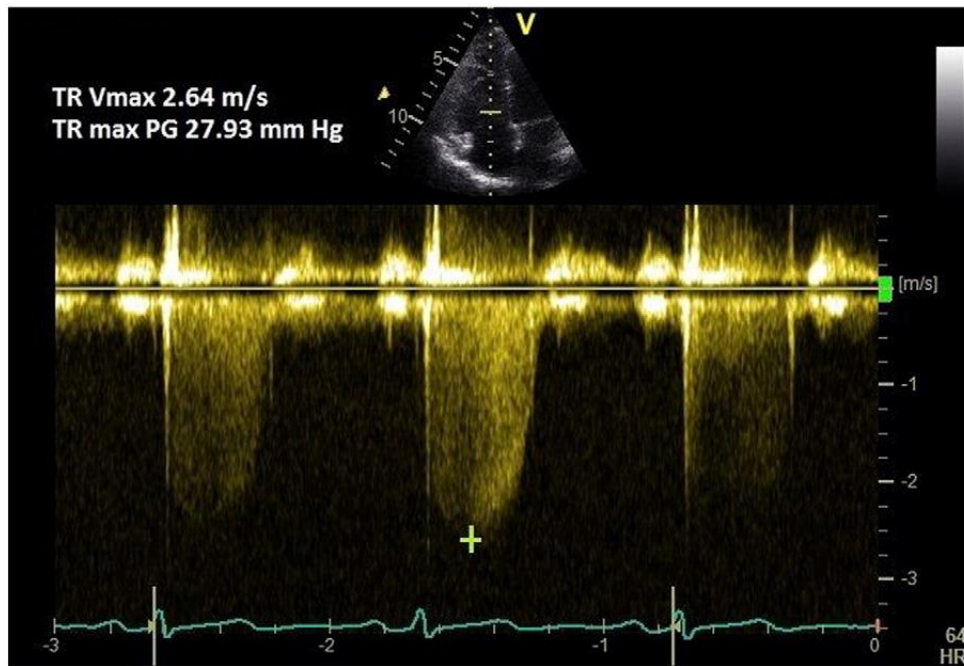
Echocardiographic assessment of PH.
